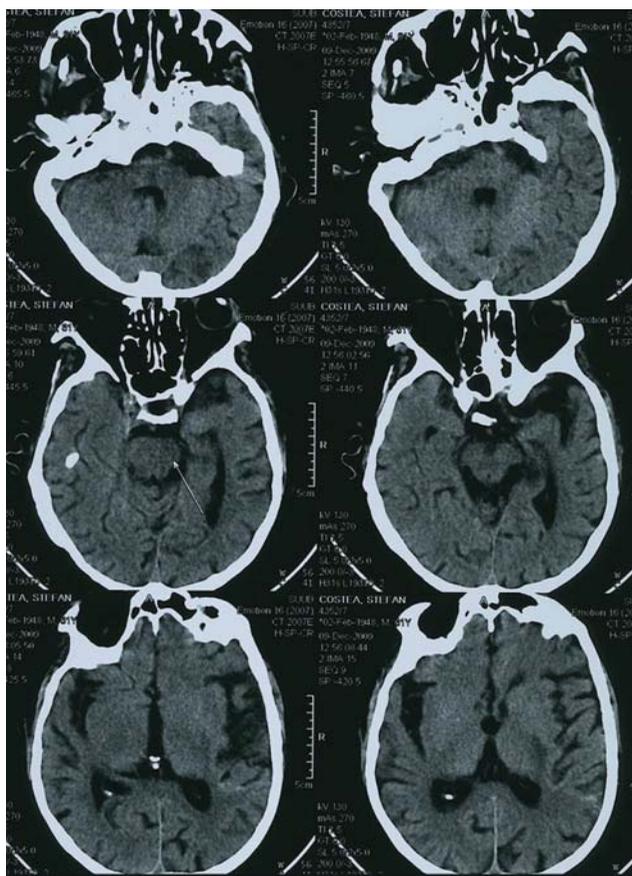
Cerebral CT scan showing ischemic lesions situated in the left side of the pons and mesencephalon
